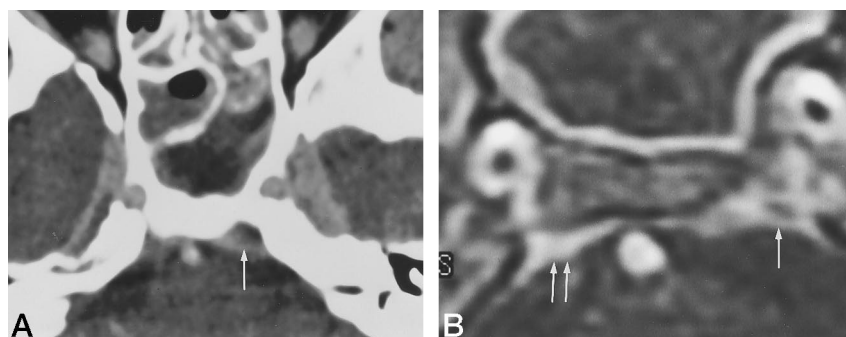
Axial contrast-enhanced CT scan (A) and corresponding contrast-enhanced SPGR MR image (B) depict left inferior petrosal sinus nonopacification and expansion (single arrow), indicating thrombosis. Note normal right inferior petrosal sinus (double arrows).
